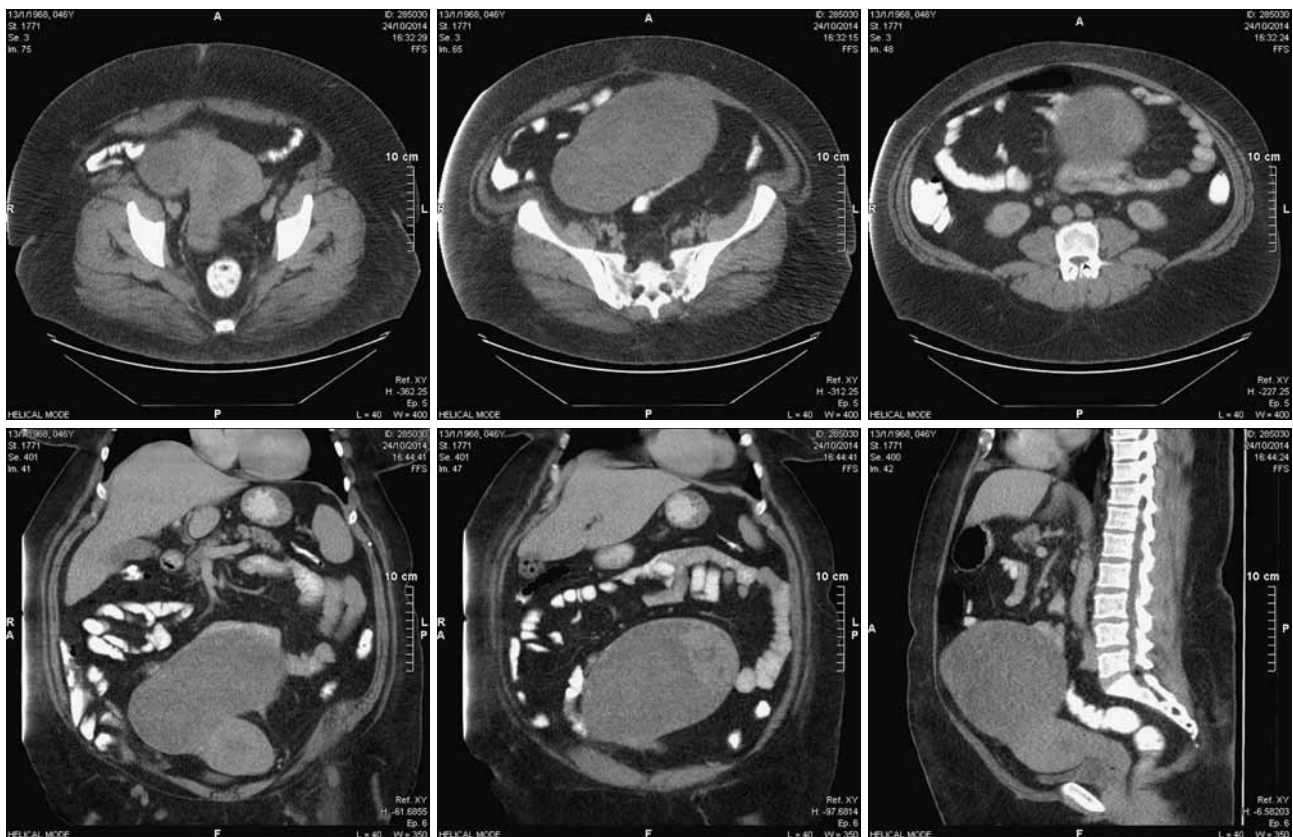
Computed tomography of the large intraabdominal tumour, showing central necrosis and locally strong and heterogeneous contrast enhancement, reaching from the mesenteric root to the right parauterine space, adjacent to small bowel loops and sigmoid and causing an imprint in the uterus.
